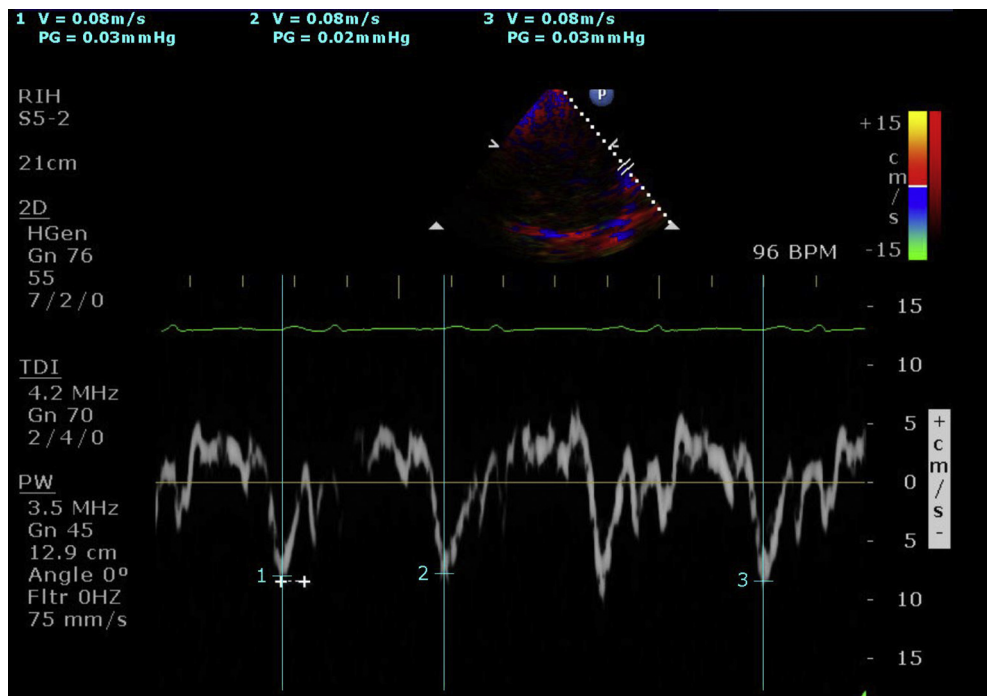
Tissue doppler imaging of lateral mitral annular velocity revealing a low early diastolic mitral annular velocity of 8 cm/s.
